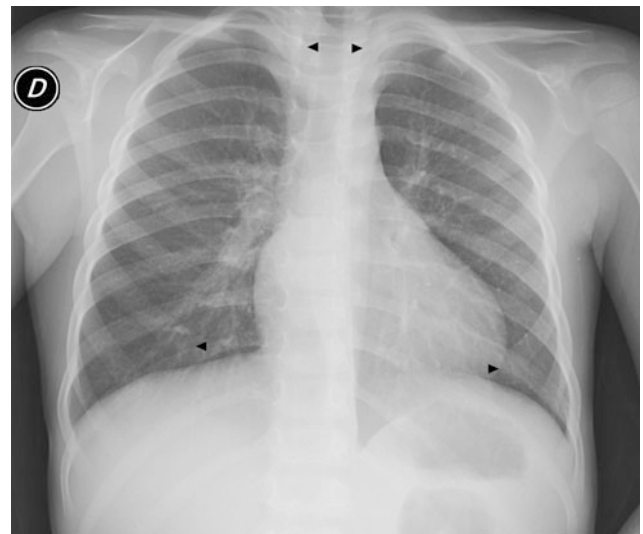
Frontal chest radiograph showing symmetry at the level of the clavicles (upper arrowheads). Note however the asymmetry in the length of the anterior costal arches in both hemithoraces (lower arrowheads) due to rotation of the inferior thorax
